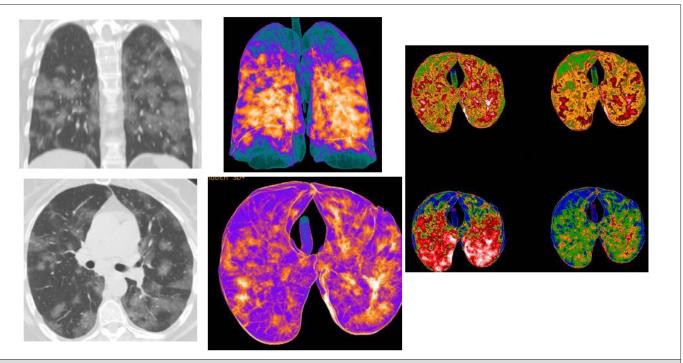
CT patterns of bilateral Covid-19 pneumonia of a 60-year-old female patient. MPR (coronal and axial) reconstructions showed: multiple bilateral consolidations areas, with bilateral interstitial thickenings, and few "ground-glass" areas. In the Volume Rendering (VRT) "colored" reconstructions (three images), the blue/green areas represented the normal lung parenchyma (also in the ventral and dorsal areas), while orange/white and red areas indicate the inflammatory pulmonary involvements, with consolidations.
